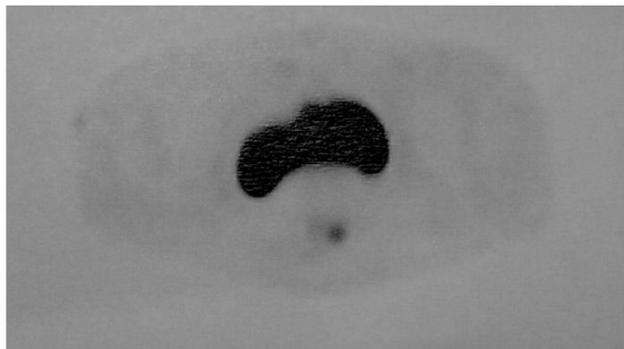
A small focus of avid FDG uptake in precoccygeal area on FDG-PET corresponding to size significant lymph node on CT.
